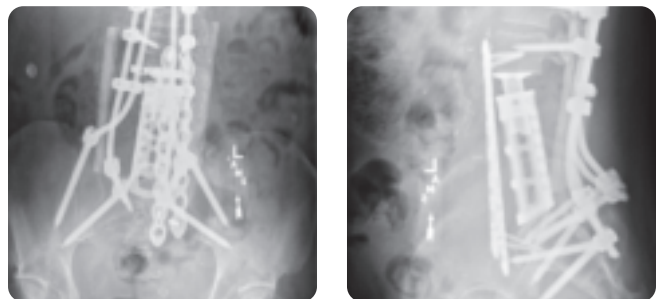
Postoperative standing X-rays showing the final spinal reconstruction.
